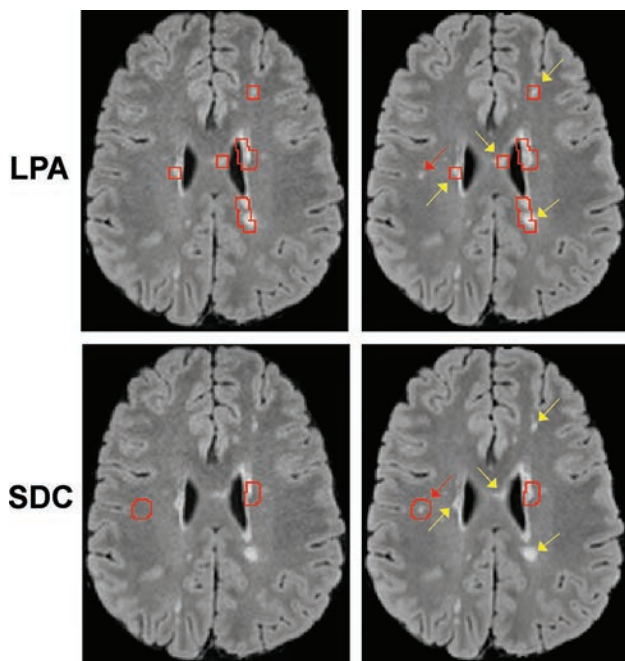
Comparison of lesion changes identified by the LPA and SDC (indicated by the red ROIs generated by the algorithms and superimposed on the T2 source FLAIR images). Each column shows images acquired at a different time points. The LPA identifies more false-positives (yellow arrows) yet misses a new small lesion (red arrow). The SDC correctly classifies positive lesion changes in concordance with the human expert.
